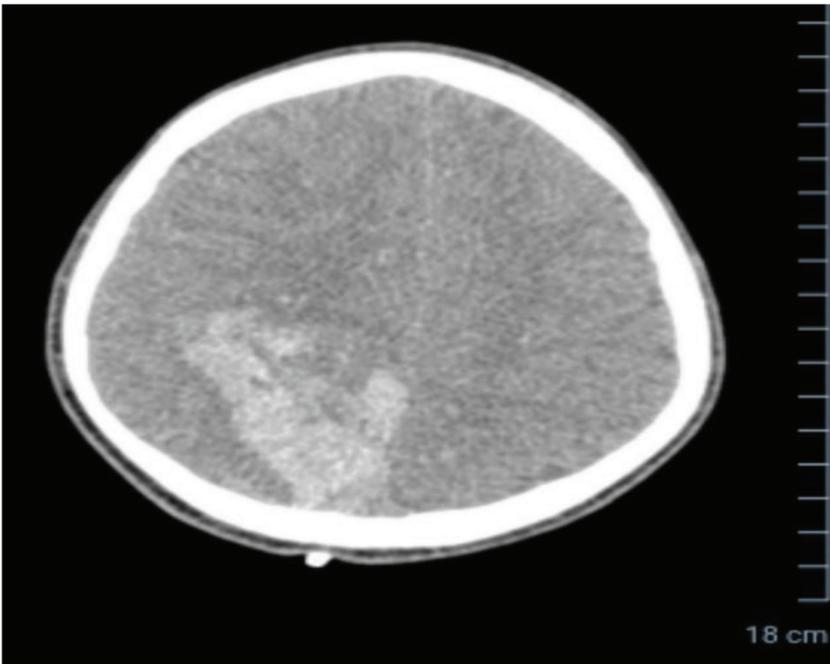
Head CT-scan axial cross section showing an intracerebral hemorrhage with volume + 58 cc with midline shift + 2.6 mm.
